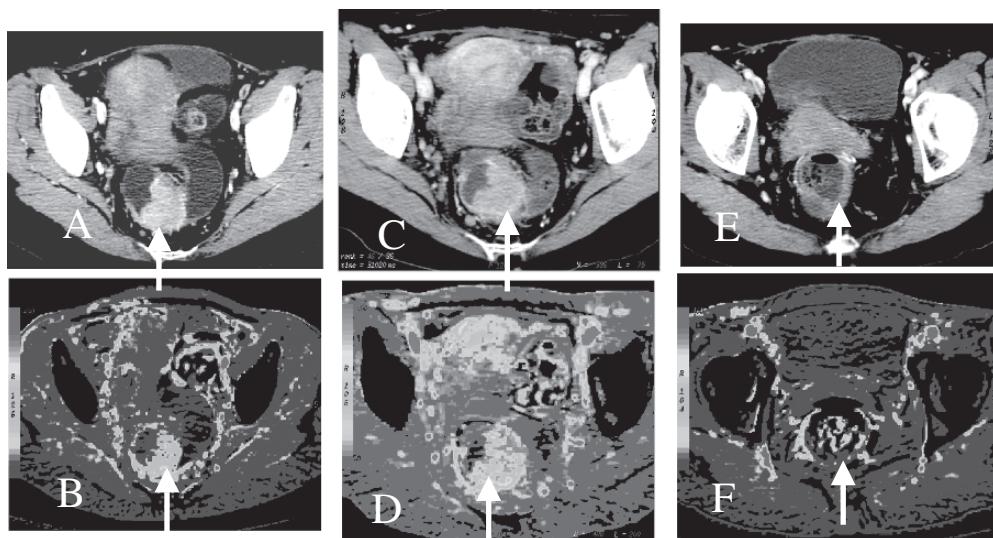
Fifty-year-old woman with rectal adenocarcinoma undergoing treatment with neoadjuvant chemoradiation that composed of initial bevacizumab (anti-angiogenic drug) followed by chemotherapy and radiotherapy. Serial contrast-enhanced CT (A = baseline, C = post-anti-angiogenic therapy, E = post-chemoradiation) and corresponding blood flow maps (B, D, F, respectively) are shown. (A) Baseline contrast-enhanced CT demonstrates a polypoidal enhancing mass (arrow) in the rectum with high tumor blood flow (arrow) seen on perfusion map (B). Follow-up imaging (C, D) performed after 2 weeks of initiation of bevacizumab therapy shows no change in tumor size (C, arrow), with about 45% reduction in tumor blood flow (D, arrow). Images from scan done at 6 weeks post-chemoradiation show almost complete resolution of the tumor (E, arrow) with normalization of blood flow (F, arrow). (Please see color insert.)
